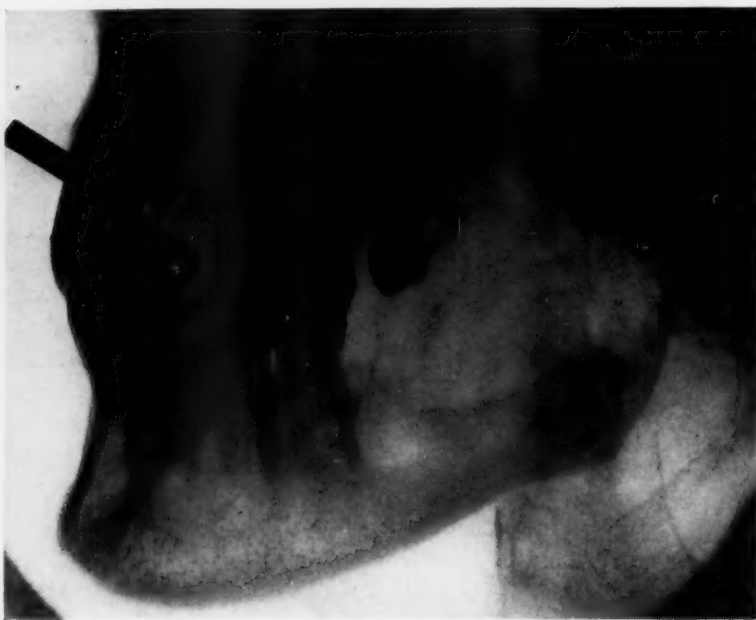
(Case 1.) Roentgenogram showing multilocular cystic adamantinoma of body and ascending ramus of left mandible.
